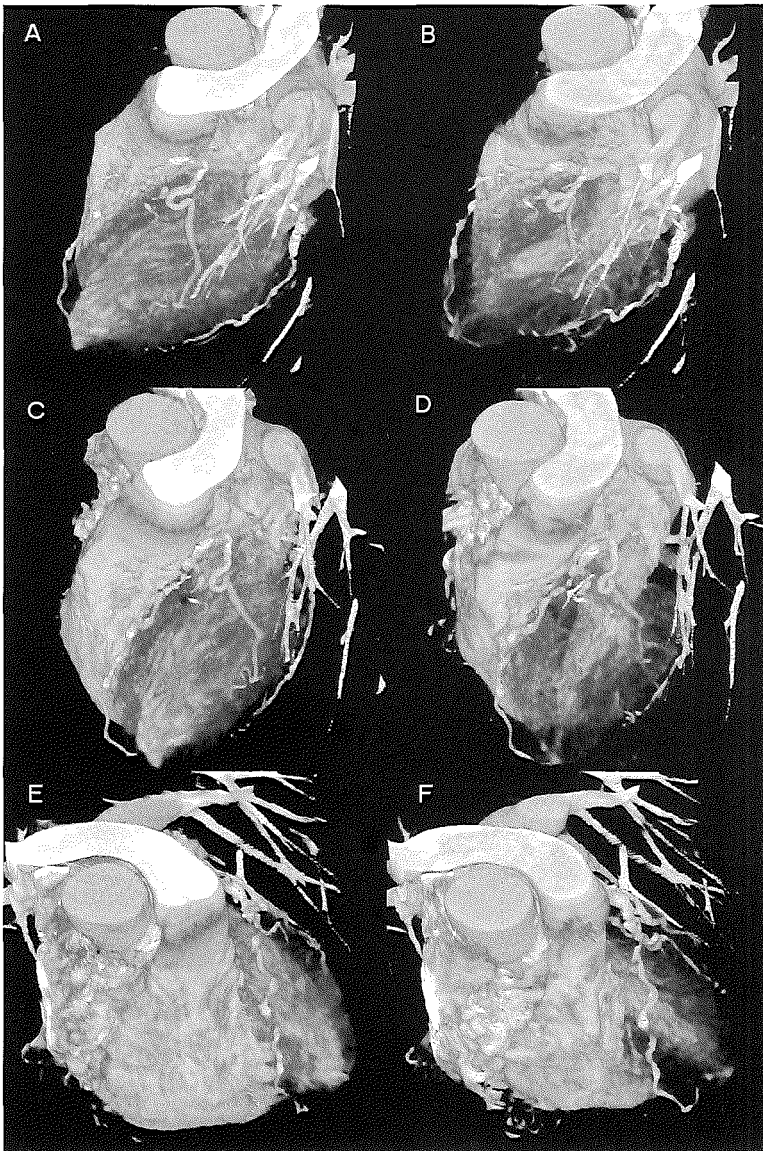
Still frames from an animated movie prepared by sequencing volume rendered CT angiograms at consecutive, temporarily overlapping cardiac phases, at a slowly changing view angle, creating the impression of a beating heart.
